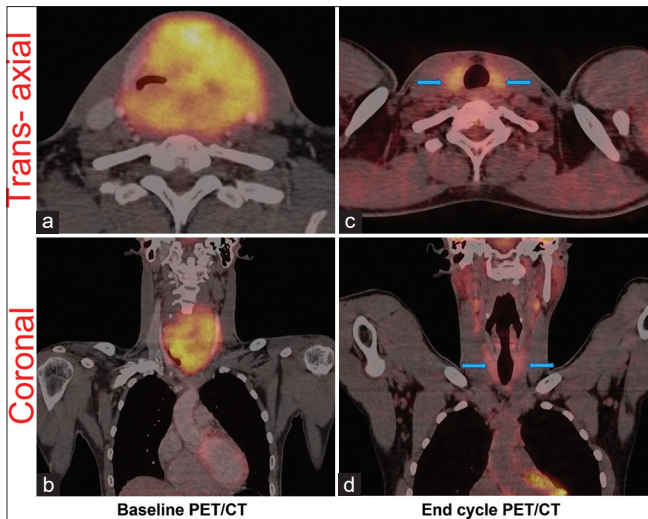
Baseline Fused FDG PET/CT transaxial and coronal images (a and b) revealed a large mass lesion in the bilateral thyroid lobe region (predominantly on the left side) with increased tracer uptake, it is displacing the trachea towards the right side. Fused transaxial and coronal End cycle PET/CT after completion of chemotherapy revealed complete resolution of thyroid mass with diffuse FDG uptake in the bilateral thyroid lobe (c and d)
